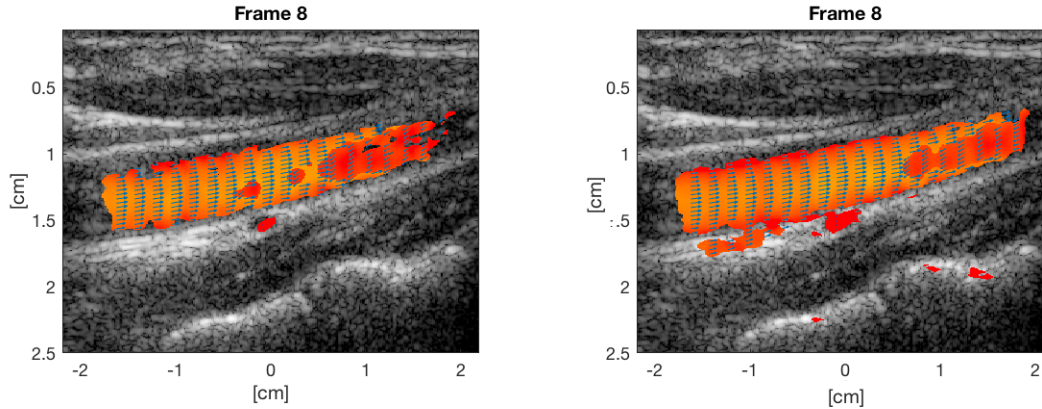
Left panel: Blood flow of the healthy volunteer with vector velocities overlaid before aliasing correction. A Doppler packet size of 50 was used in acquisition. Right panel: the corresponding image using a packet size of 150.
